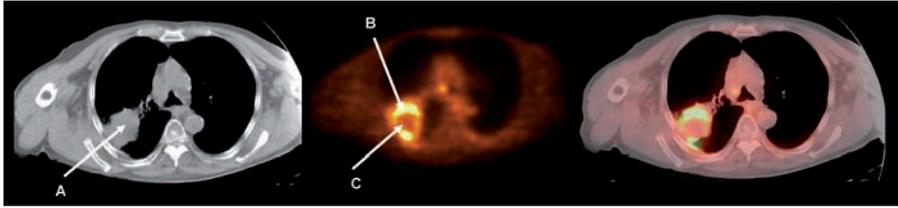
PET (central image) and CT images (left side image) of a patient with right lung carcinoma CT study shows an abnormal mass (A) that cannot be characterized. The PET study shows glucose uptake in the periphery of the lesion indicating the presence of viable tumour tissue (B) and no uptake in the centre, indicating central necrosis. (C) Combining PET/CT (right side image) is ideal for directing the biopsy to the active edge of the lesion.
